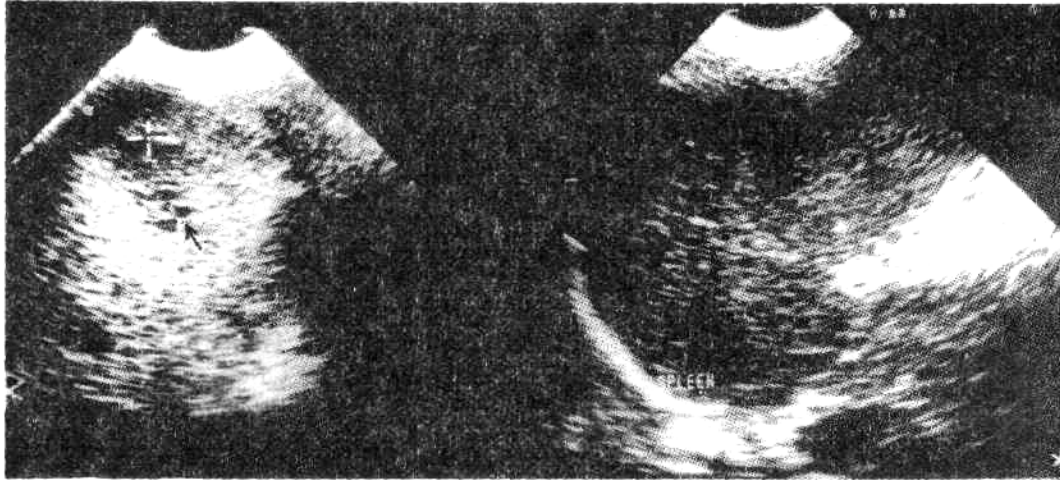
Ultrasound picture showing multiple hypoechoic lesions in the spleen (left, marked with arrow) and the follow up ultrasound done after 3 months of treatment showing absence of the lesions (right).
